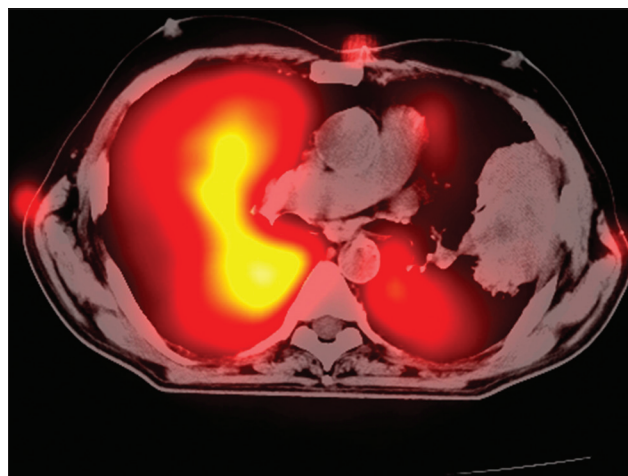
The accuracy of the registration was evaluated by the superposition of the fiducial markers of the single photon emission computed tomography overlaid image on the computed tomography
